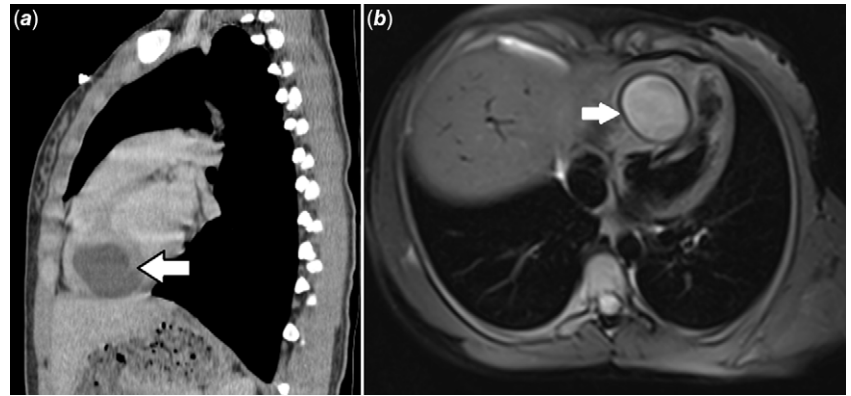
Sagittal CT image (a) shows a smooth, round cystic lesion (white arrow) extending towards the inferior surface of the heart. Axial T2-weighted image (b) shows a round, hyperintense, multilocular cystic lesion (white arrow), containing hypointense areas in IVS close to the apex.
